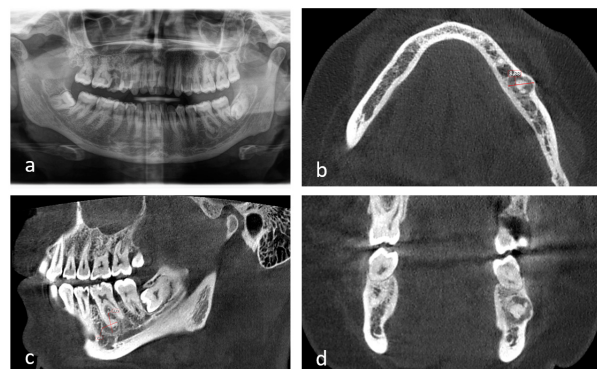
a. Panoramic radiography of the second follow-up session (year 2020), b. A well-defined mixed lesion was observed. The internal opaque contents were observed to be thicker compared to the initial radiograph, c. Minimally increased dimensions of the lesion, d. CBCT showed minimally increased expansion in the axial plane (Fig. 2b) and coronal plane and thinning of the buccal cortical plate in the axial and coronal planes.
